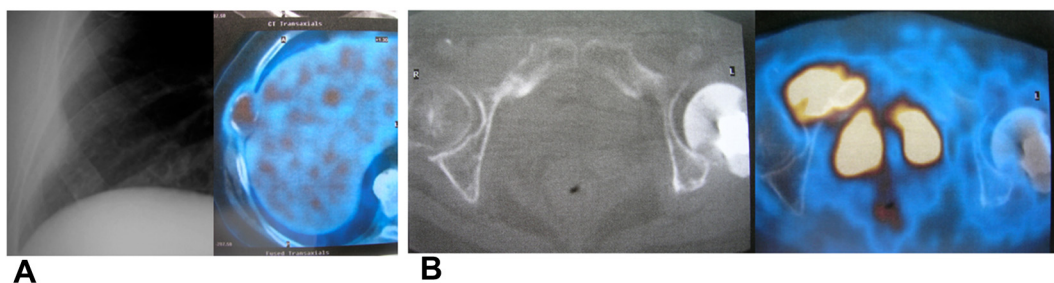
Positron emission tomography–computed tomography showed (A) metastasis to the right seventh rib and (B) recurrence of gastrointestinal stromal tumour in the pelvis with local invasion into the right groin. No significant uptake over the left acetabulum was noted.
